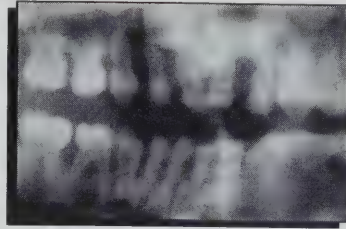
Section of panoramic radiograph revealing advanced bone loss in primary dentition of patient with Papillon-Lefevre syndrome.
